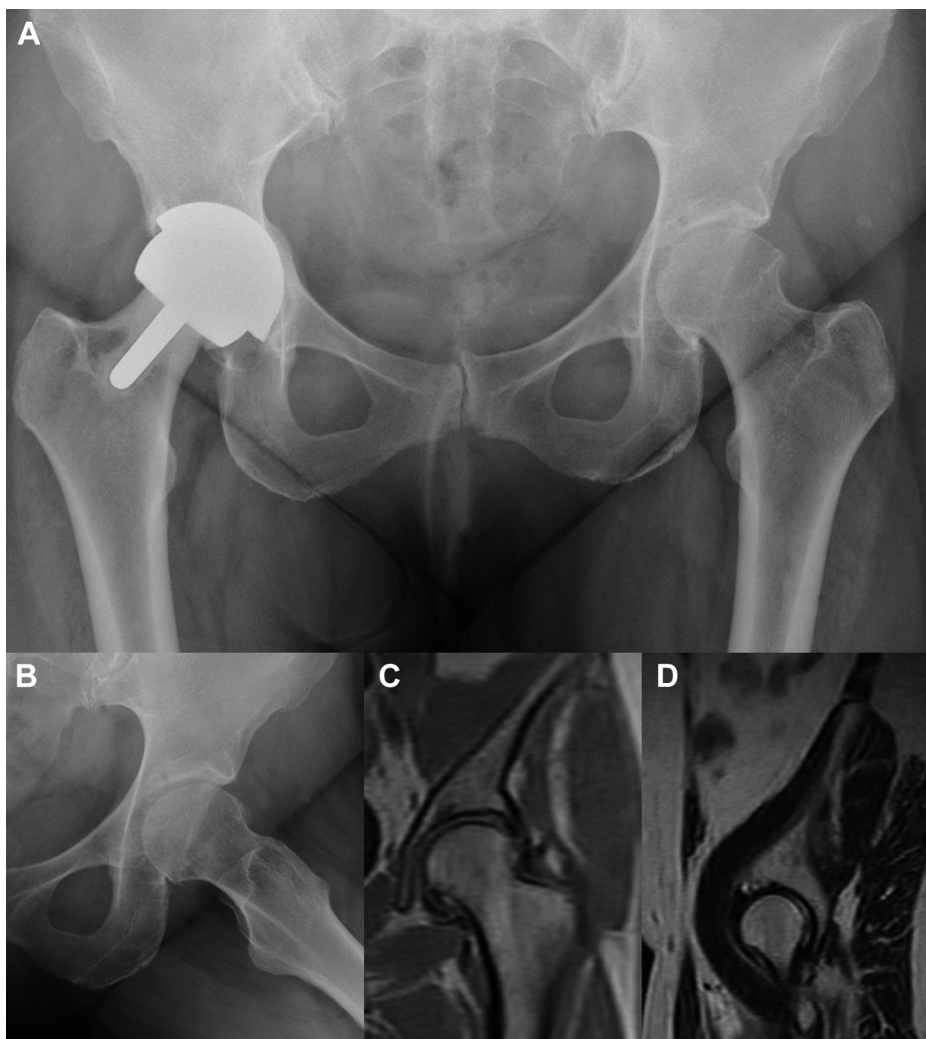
Preoperative images. A 58-year-old woman with left hip pain of 6 months' duration. The impingement test result was positive, and her pain was located in the left groin. The joint space was well maintained and loss of femoral head-neck offset and asphericity (cam lesion) in the left hip are shown in the (A) anteroposterior pelvic and (B) axial hip views. Right hip resurfacing arthroplasty was performed, with a 4-year follow-up. No evidence of osteonecrosis of the left femoral head is seen in (C) coronal T1-weighted magnetic resonance images and (D) sagittal T2 magnetic resonance images.
